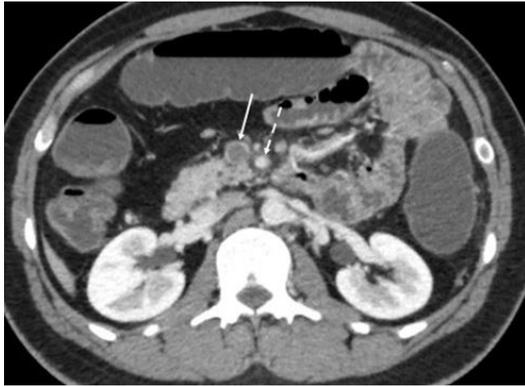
A contrast-enhanced CT abdomen of a 35-year-old man with acute abdominal pain and distension shows absence of contrast (filling defect) in the SMV (solid white arrow) suggesting a thrombus. Note normal enhancement of the SMA (dashed white arrow) compared to the hypodense SMV
